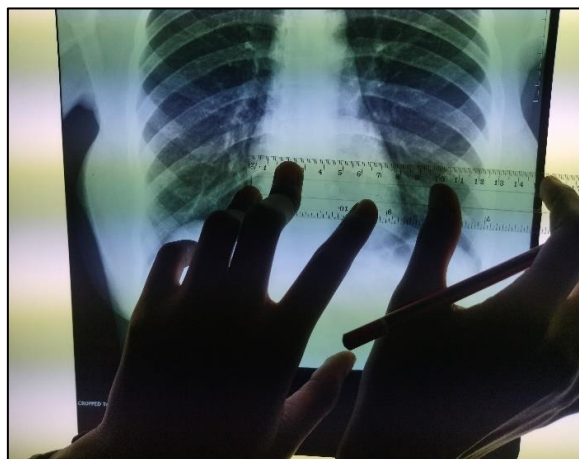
x-ray image showing measurement of the Transverse Cardiac Diameter (TCD)
